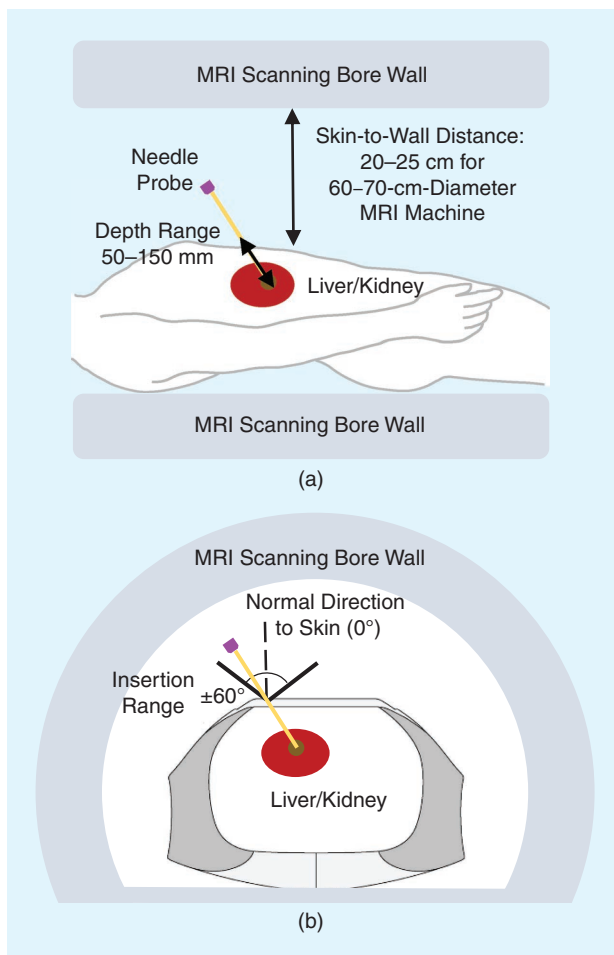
The workspace of interventional robotic systems for the liver and the kidney. (a) A side view of the patient body inside the MRI bore. (b) A section view of the body of the patient in the axial/transverse plane.
